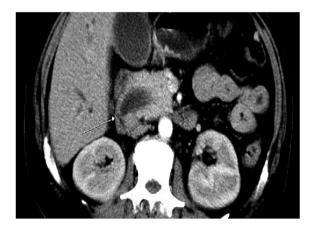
Contrast enhanced computerised tomogram. CT scan showing asymmetric thickening of lower end of the common bile duct with distended gall bladder and dilated intra and extra hepatic biliary radical, indicative of periampullary carcinoma.
